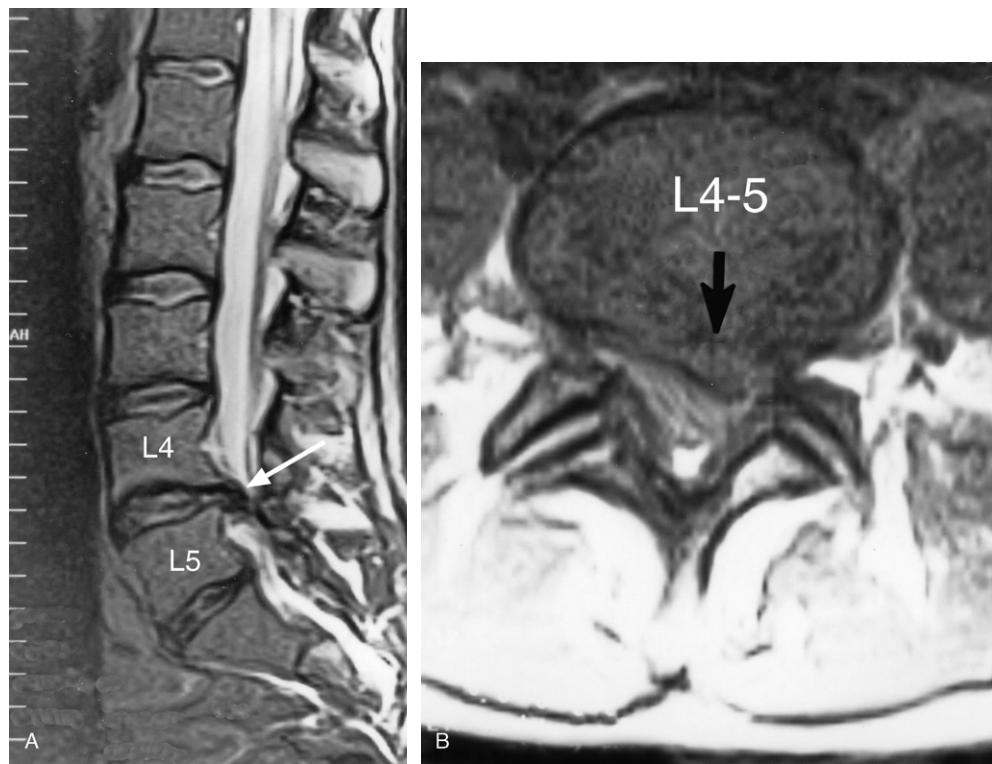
(A) Lumbar spine MRI slightly left parasagittal T2-weighted image. Note the moderate sized L4–5 intervertebral disc protrusion posteriorly (arrow). At L5–S1 level there is only a minimal posterior intervertebral disc bulge posteriorly. (B) MRI axial T2-weighted image at the L4–5 level. Note the L4–5 level moderate sized central to left paracentral disc protrusion impinging upon the left L5 nerve root and intervertebral foramen.
